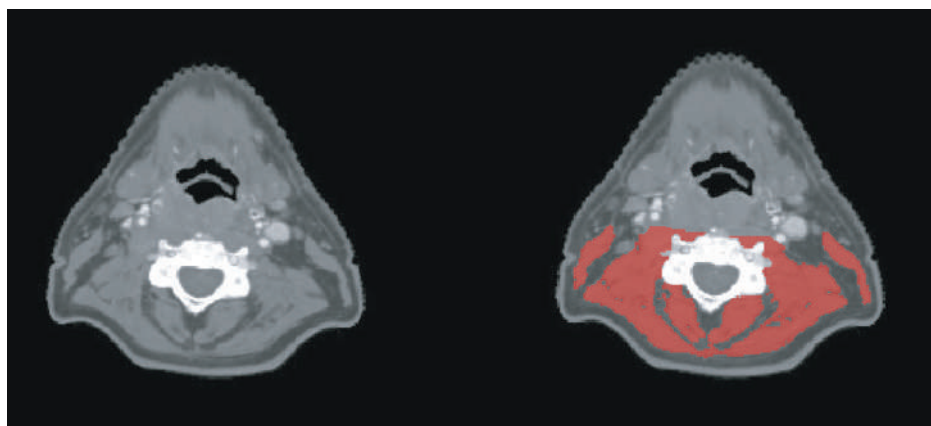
Figure shows two identical axial CT-slides at the level of C3; left shows the muscle tissue unsegmented, right shows both sternocleidomastoideus and paravertebral muscles segmented in red.
